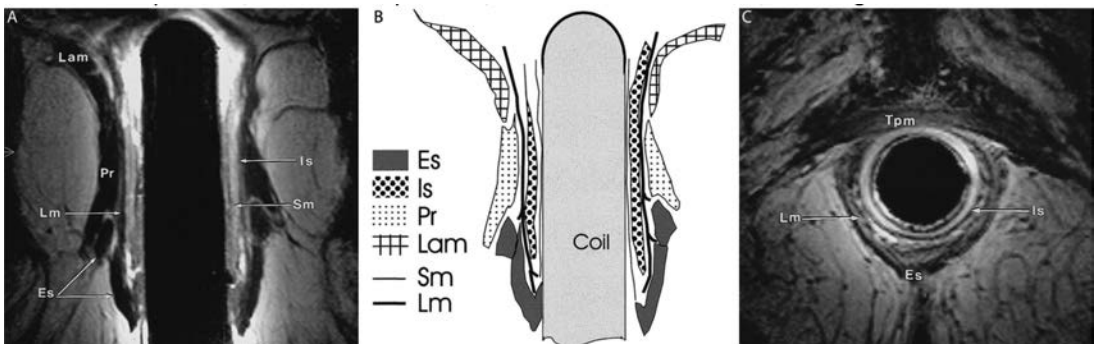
Figure C 6: Weighted turbo spin-echo endoanal coil MRI studies by Rociu et al.[22,23]
